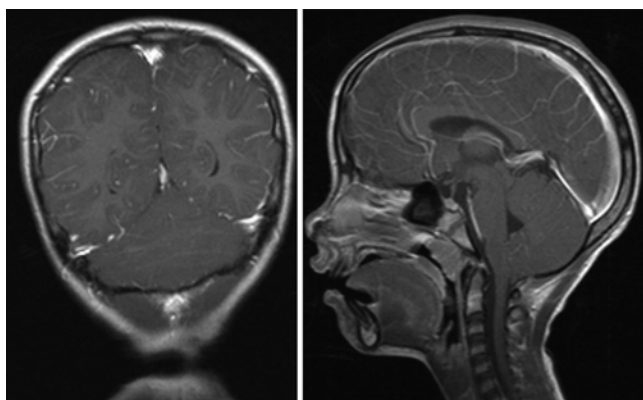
Case 5. Left: Coronal T1-weighted Gd-enhanced image showing complete fusion of the cerebellar hemispheres, consistent with RS. Right: Rhombencephalosynapsis in conjunction with Chiari malformation Type I. Sagittal Gd-enhanced T1-weighted image demonstrating cerebellar tonsillar ectopia extending more than 5 mm below the foramen magnum. Although the cerebellar hemispheric fusion cannot be directly visualized, there is no recognizable vermis on this midline sagittal image.
